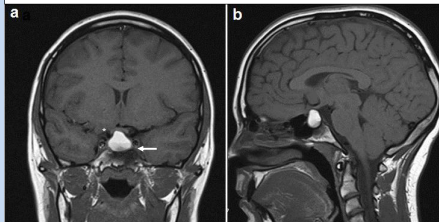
Patient 2's MRI scan of pituitary post-surgery
